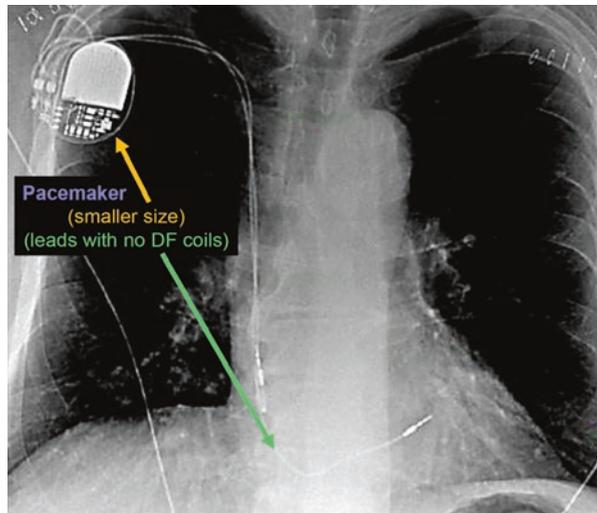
Anterior posterior chest x-ray showing a pacemaker
